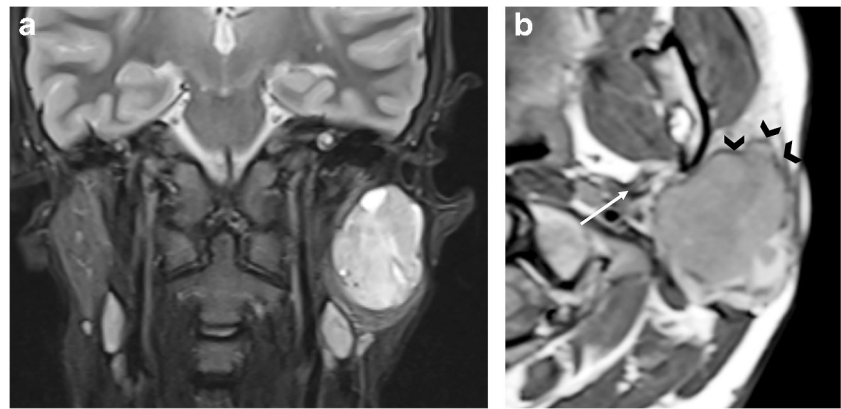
A 14-year-old boy with left parotid pleomorphic adenoma. a Coronal STIR (short tau inversion recovery) image shows the mass appears well circumscribed with T2 heterogeneously hyperintense signal. b Axial T1-weighted image shows effacement of the left parapharyngeal fat (*arrow*) by the pleomorphic adenoma and demonstrates a hypointense external capsule (*arrowheads*)
